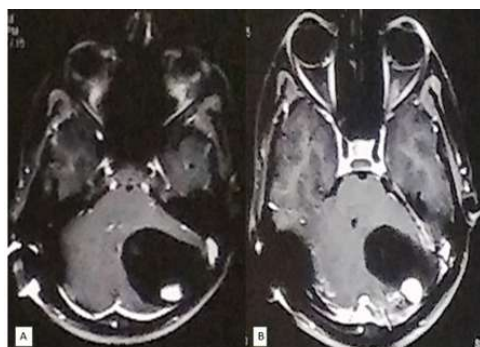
(A) & (B) Contrast enhanced MRI shows a cystic lesion with intensely enhancing mural nodule in left cerebellum.
